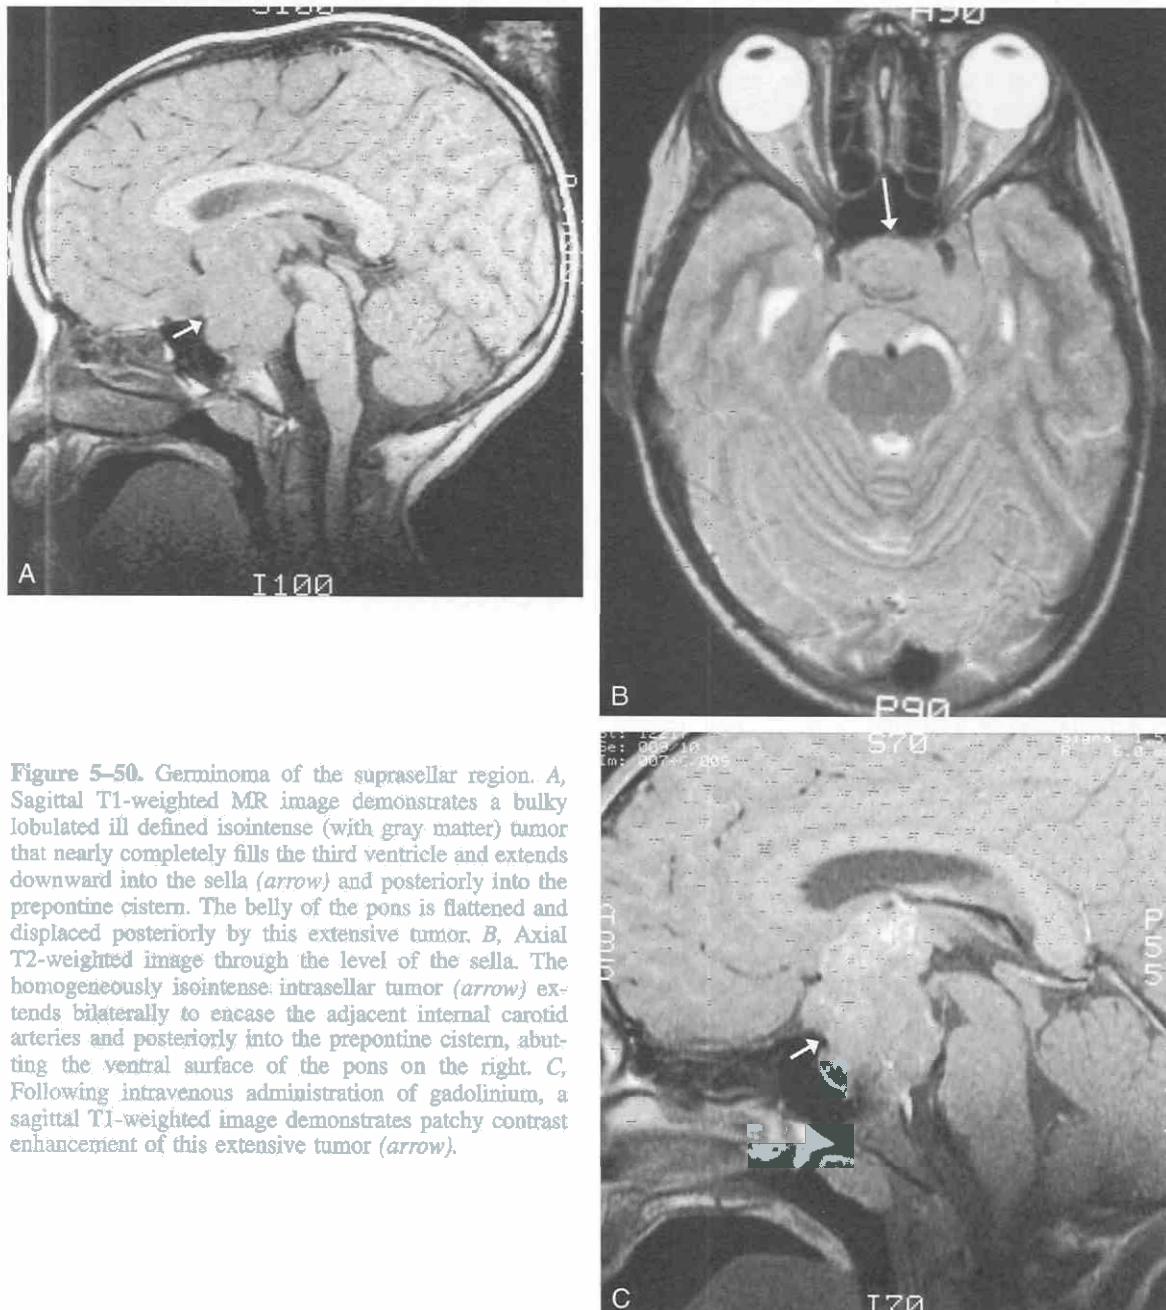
Germinoma of the suprasellar region. *A*, Sagittal T1-weighted MR image demonstrates a bulky lobulated ill defined isointense (with gray matter) tumor that nearly completely fills the third ventricle and extends downward into the sella (arrow) and posteriorly into the preoptine cistern. The belly of the pons is flattened and displaced posteriorly by this extensive tumor. *B*, Axial T2-weighted image through the level of the sella. The homogeneously isointense intrasellar tumor (arrow) extends bilaterally to encase the adjacent internal carotid arteries and posteriorly into the preoptine cistern, abutting the ventral surface of the pons on the right. *C*, Following intravenous administration of gadolinium, a sagittal T1-weighted image demonstrates patchy contrast enhancement of this extensive tumor (arrow).
